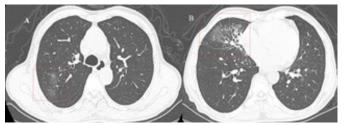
Images of a 70-year-old man with a history of full COVID-19 vaccination and no comorbidities. He complained of a cough for five days and hemoptysis for one day. Chest CT shows unilateral multifocal ground-glass opacity with bronchiectasis. The CT severity score (CT-SS) was 5. This case was classified as having an indeterminate appearance of COVID-19 according to the RSNA chest CT classification system.
